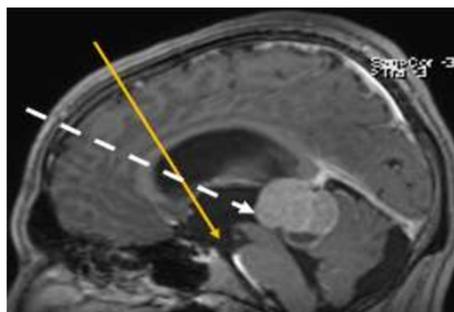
Preoperative sagittal T1 MRI with contrast showing the trajectory for an ETV (yellow arrow) and the trajectory for pineal region tumor biopsy (white dotted arrow)
